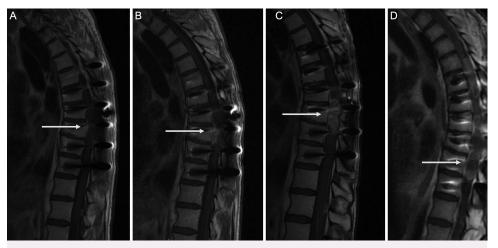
Case 1. Sagittal T1-weighted postcontrast sequences with initial postoperative imaging (A) demonstrating a small amount of residual disease (*arrows*) and subsequent follow-up imaging demonstrating progression at 9 months (B), 1 year (C), and 2 years (D) despite interval repeat resection at 1 year.
